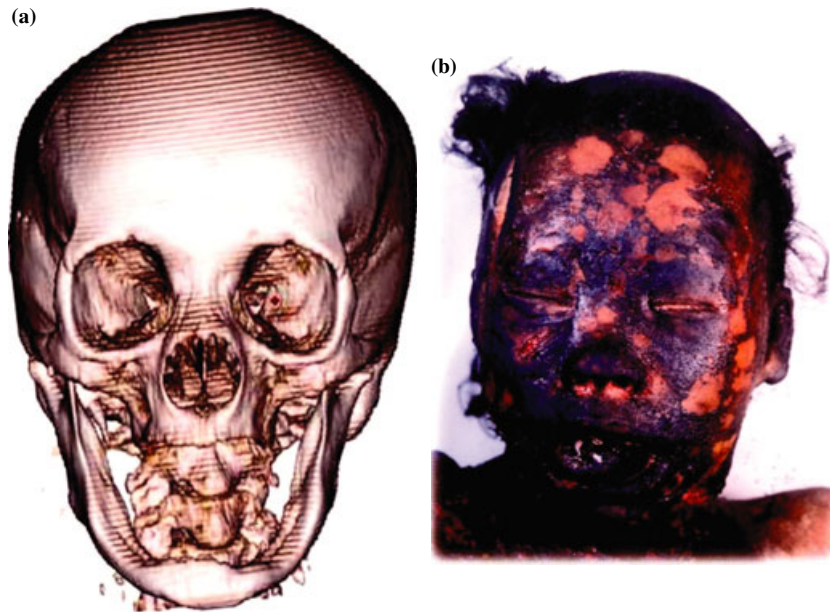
The case of the burned body: (a) 3D-CT image, and (b) the picture in forensic autopsy.
